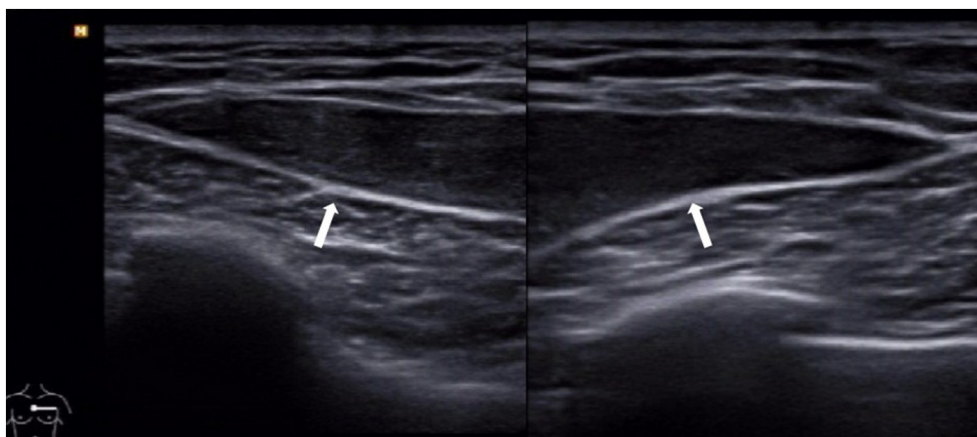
Breast ultrasonography, performed at an outside hospital, shows a circumscribed, oval, and homogeneously hypoechoic mass in the subcutaneous fat (white arrows).
